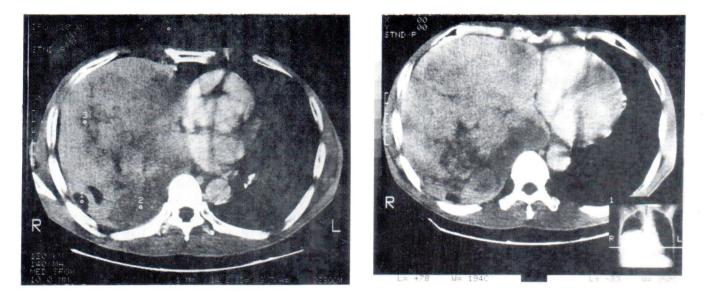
I.V. contrast axial CT scan of the chest showed a well defined border mass with isodensity to mildly hypodensity to the adjacent heart and aorta. Multiple small low density areas were noted.
